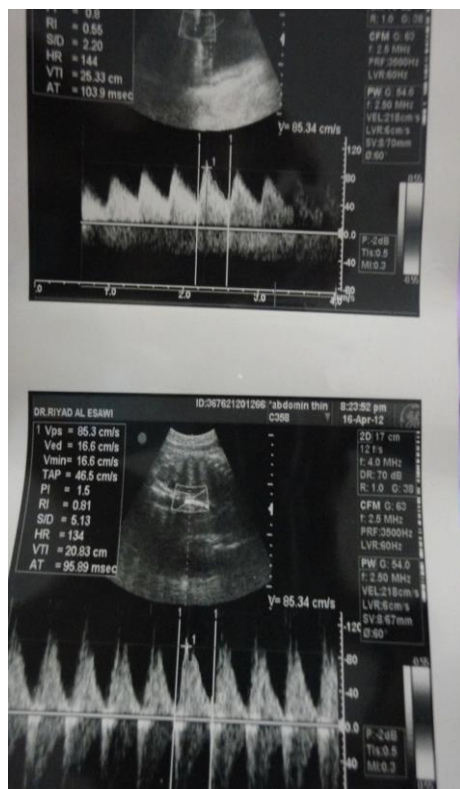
Doppler wave forms of AU (above) & Ao (below) at 39 weeks of gestation.
